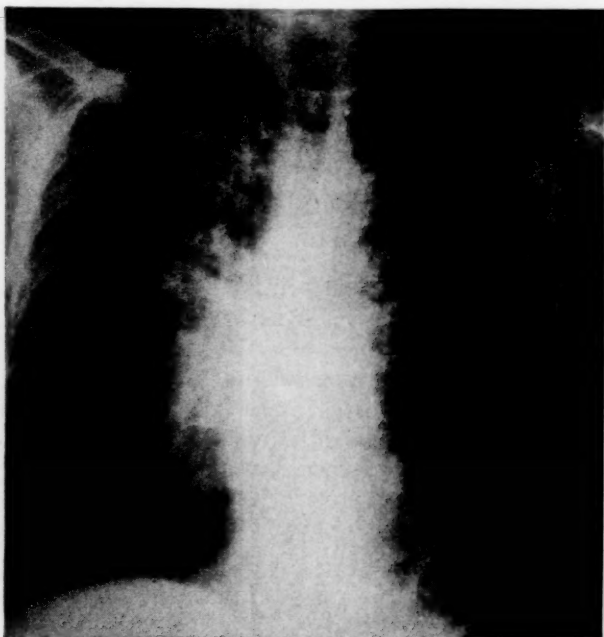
X-ray taken twelve days after completion of radiation therapy, Case II.
